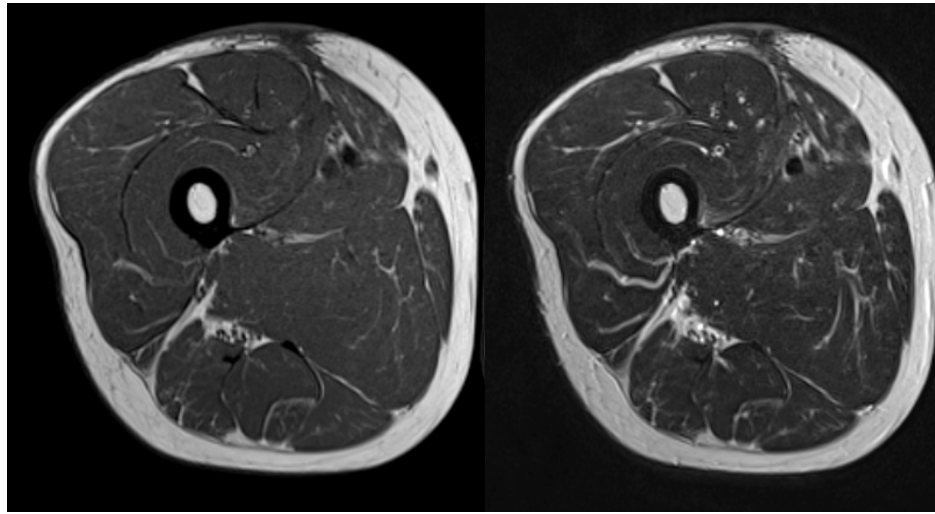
Magnetic resonance images, 3 months postoperatively. A: T1-weighted axial image. B: T2-weighted axial image. There are no signs of inflammation within the muscle.
